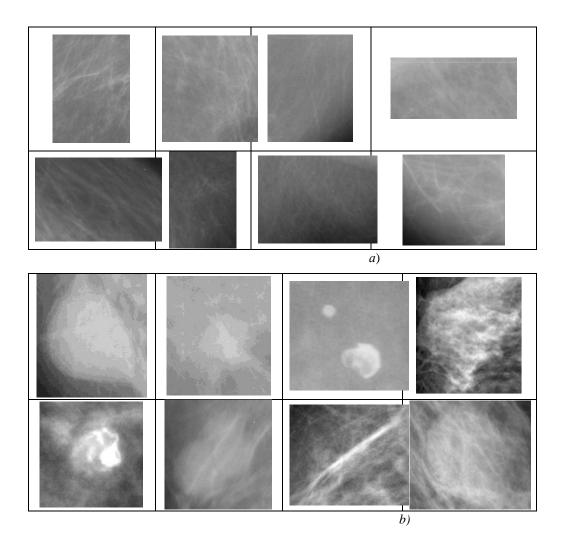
Examples of test segments of X-ray images of the breast: a) - norm; b) - pathology
